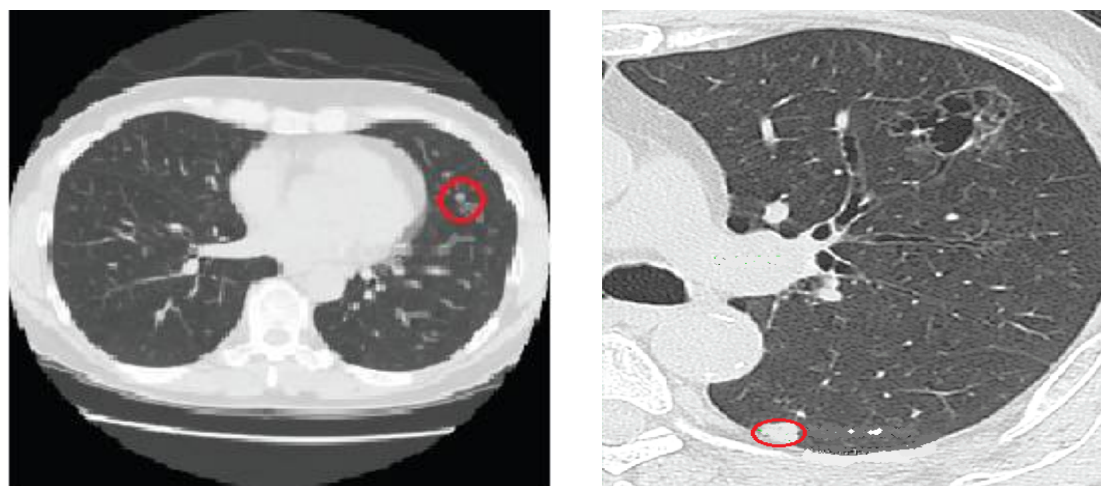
a. Low Dose CT scan showing 3mm nodule
